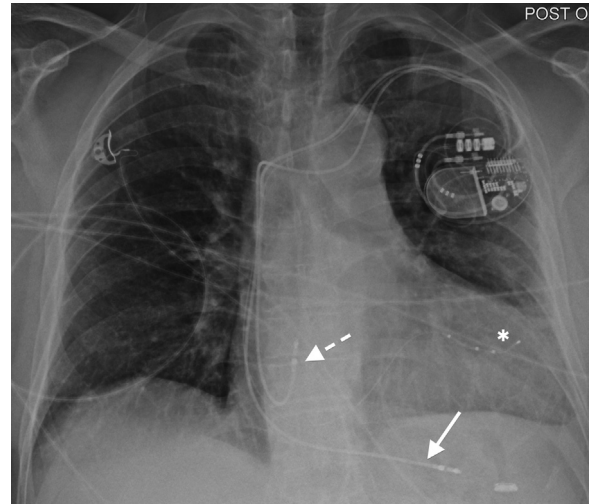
Chest radiograph demonstrating a cardiac resynchronization therapy-pacemaker device with a lead in the right atrium (dashed arrow), right ventricle (solid arrow), and coronary sinus (asterisk).
